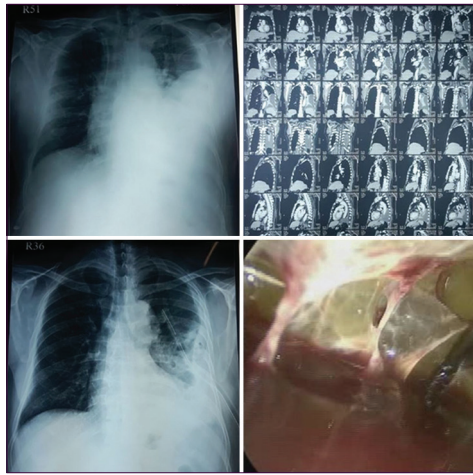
(a-d) Anti-clockwise from top left - (1) Pre-operative chest X-rays (CXR) posteroanterior (2). Post-operative day 1 CXR (3). Pre-operative computed tomography Thorax (4). Intraoperative findings - Thick loculations and empyema 67-year-old male, cough, fever, and breathlessness
